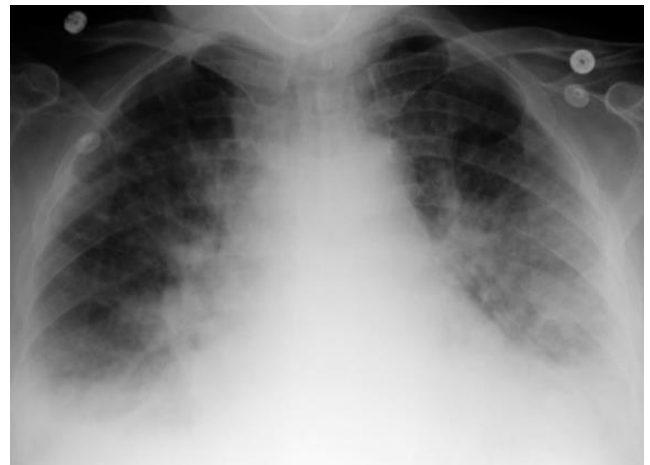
Posterior-anterior chest radiograph: Acute pulmonary edema
